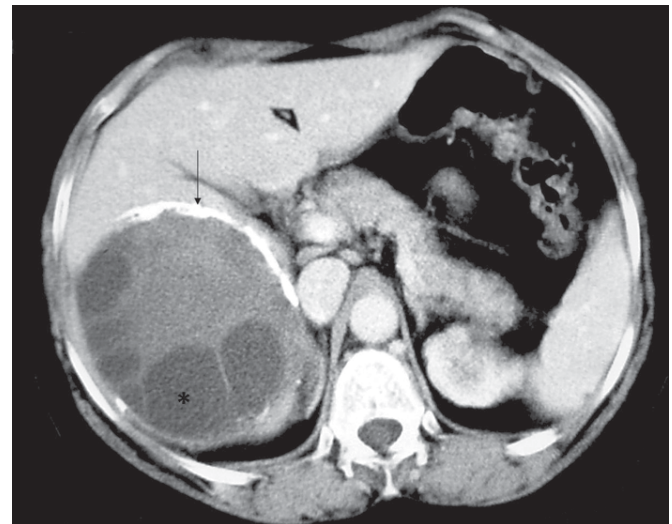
Axial contrast-enhanced CT shows the presence of a characteristic hydatid cyst with solid areas and multiple daughter cysts (asterisk) inside. The wall of the cyst is partially calcified (arrow).
